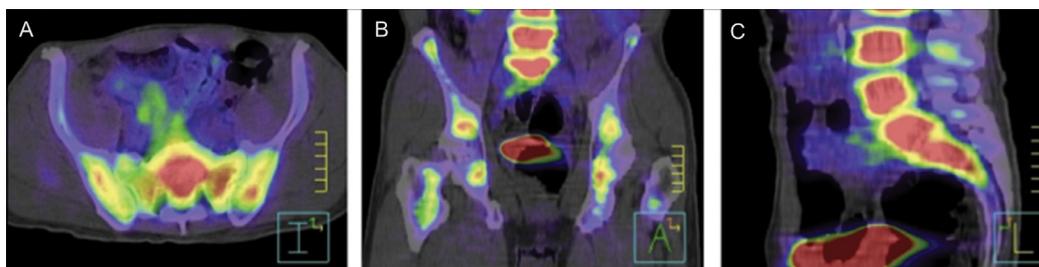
Cervical cancer. Co-registered FLT-PET and CT images in transaxial (left), coronal (middle), and sagittal (right) demonstrated FLT uptake in the bone marrow. Purple represents the lowest uptake and red the highest uptake. Reprinted with permission.³⁴
